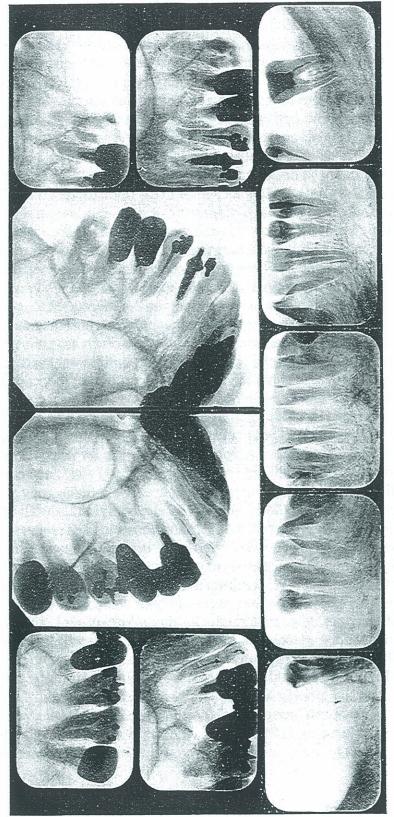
APPEARANCE OF PERIAPICAL REACTION OF PATIENT WHO HAS A HIGH DEFENSE, REFERRED TO IN FIGURE 97.
